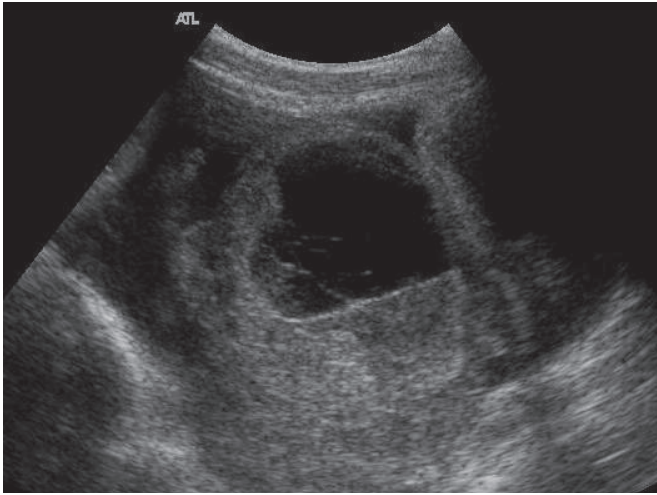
Ultrasound examination reveals a large, complex, thick-walled cystic lesion in the right adnexa, with internal septations and an echogenic area on the dependent site of the lesion suggesting a blood clot. There is also a large amount of free fluid in the pelvic region.
